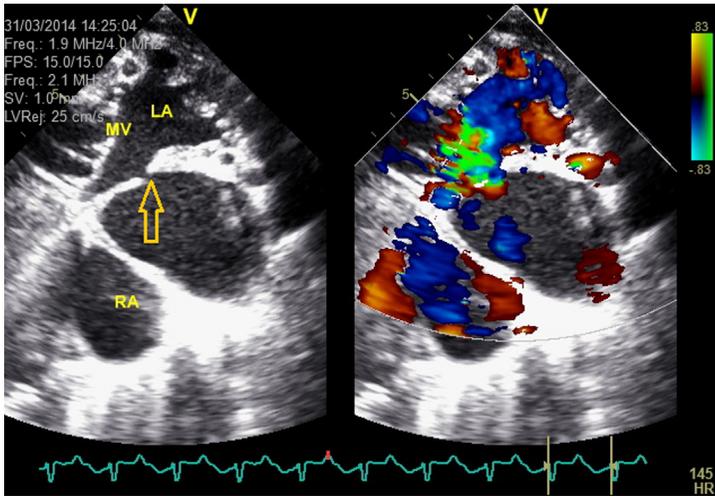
2D B-mode (*left*) and simultaneous color Doppler recording (*right*) of the left parasternal long-axis, LA view. This calf was diagnosed with cor triatriatum sinister. The LA is divided into 2 compartments with a narrow communication (*arrow*) from the upper compartment (with pulmonary veins draining into it) to the lower one (communicating with the LV and mitral valve (MV) and the RA via a large atrial septal defect [ASD]). Color flow mapping indicates turbulent flow (color coded in *green*) through the communication between compartments. Additional turbulent flow is seen in the lower LA compartment as a result of right-to-left shunting of blood across a large ASD.
